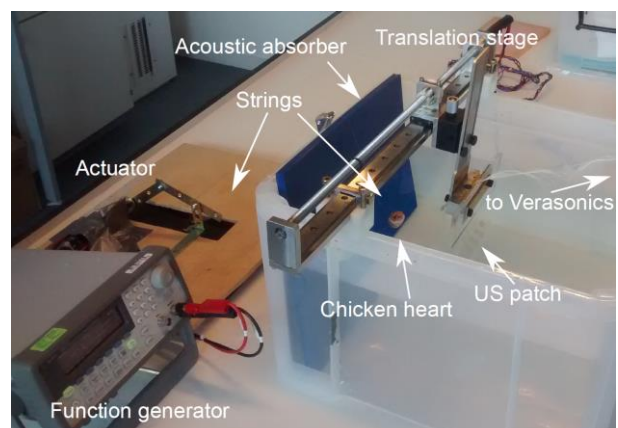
Flexible Ultrasound patch used in a dedicated *in-vitro* beating fetal heart rate setup. The function generator drives the motor with a predefined waveform. The strings attached to the motor pull on the chicken heart, causing a beat-like motion pattern at 120 beats per minute.
